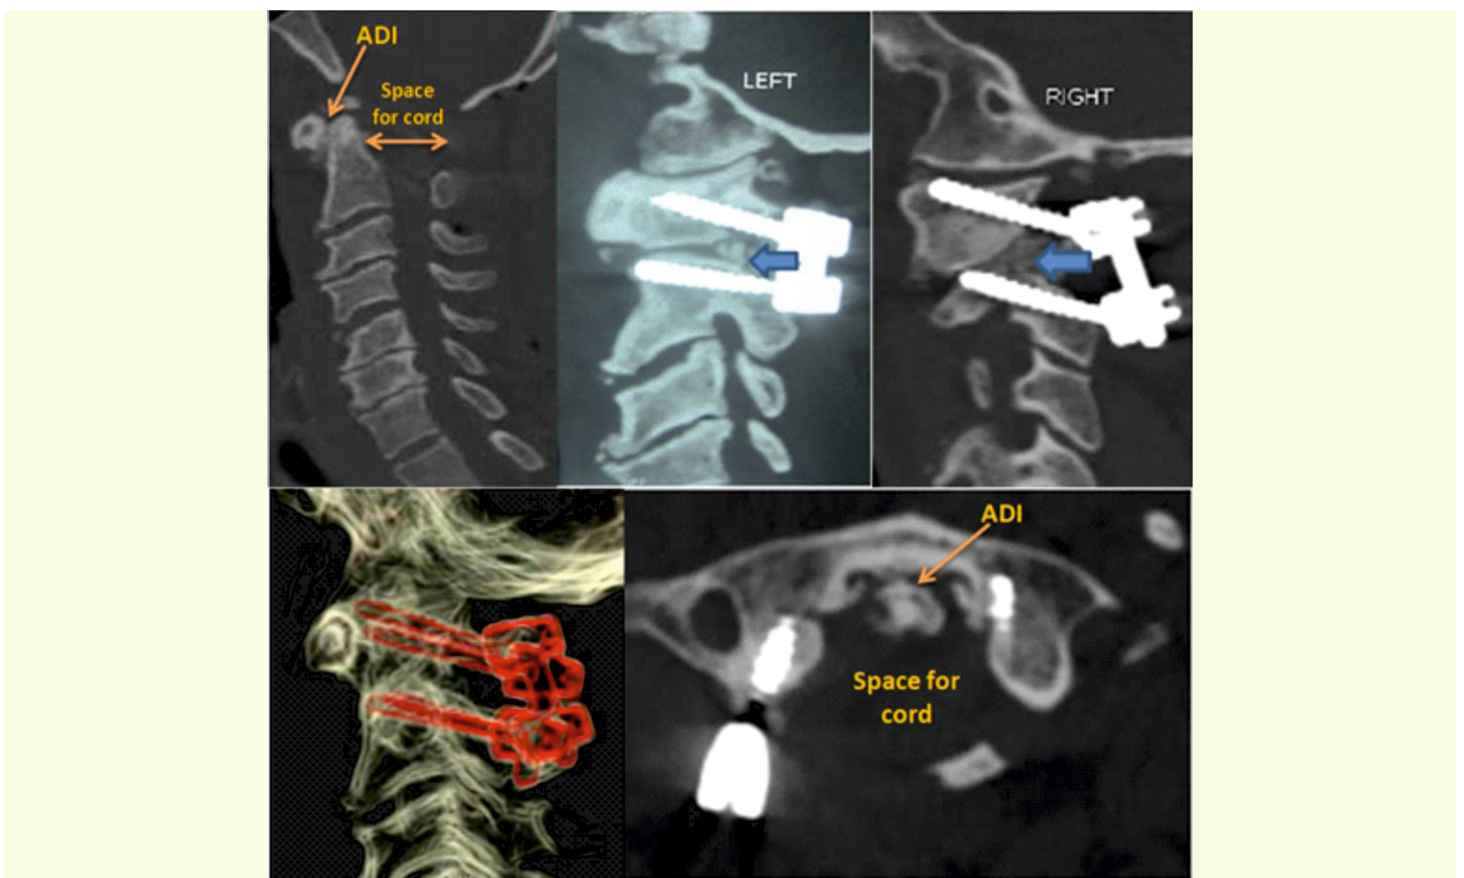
Postoperative CT images of case3 showing reduction of C1-C2 subluxation with screw-rod fixation and fusion with bone graft at C1-2 joint (Broad arrows). Note the reduction in the atlanto-dens interval (ADI) and the increase in the space available for the spinal cord.
